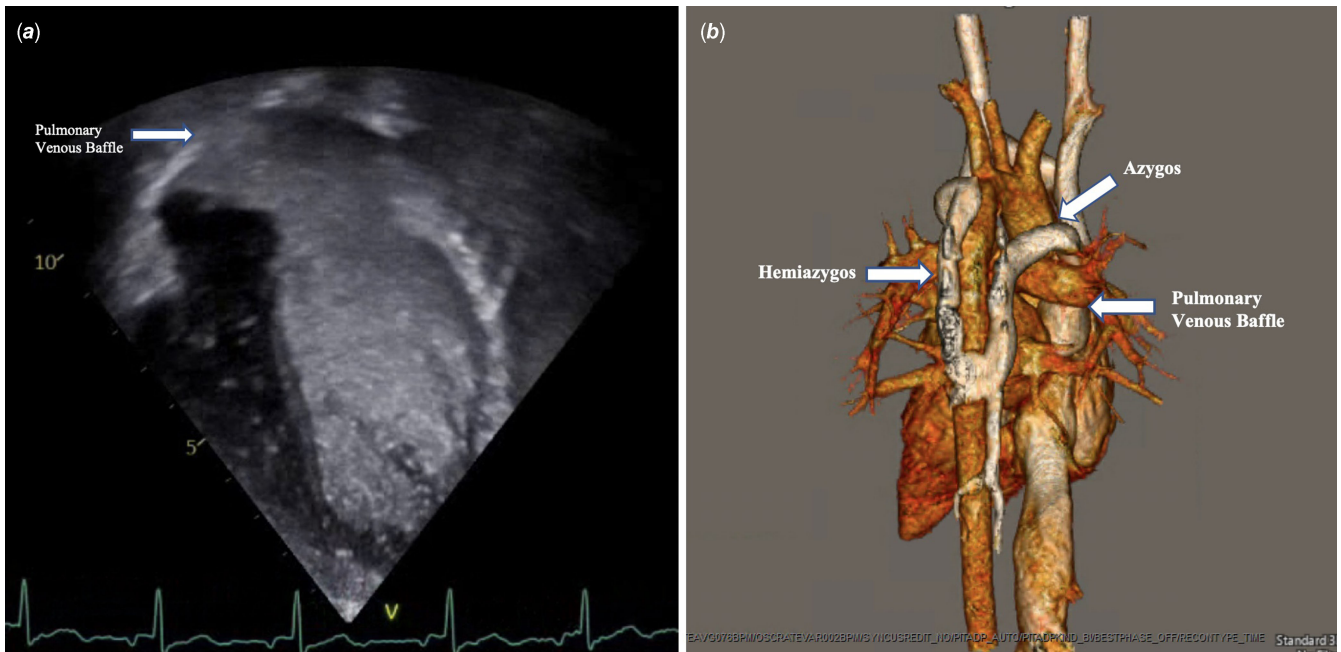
a*) Apical four-chamber view during agitated saline injection demonstrating opacification of the pulmonary venous baffle, left atrium, and left ventricle *b*) CTA 3D reconstruction demonstrating hemiazygos vein connecting to dilated azygos vein which is incorporation into pulmonary venous baffle.
